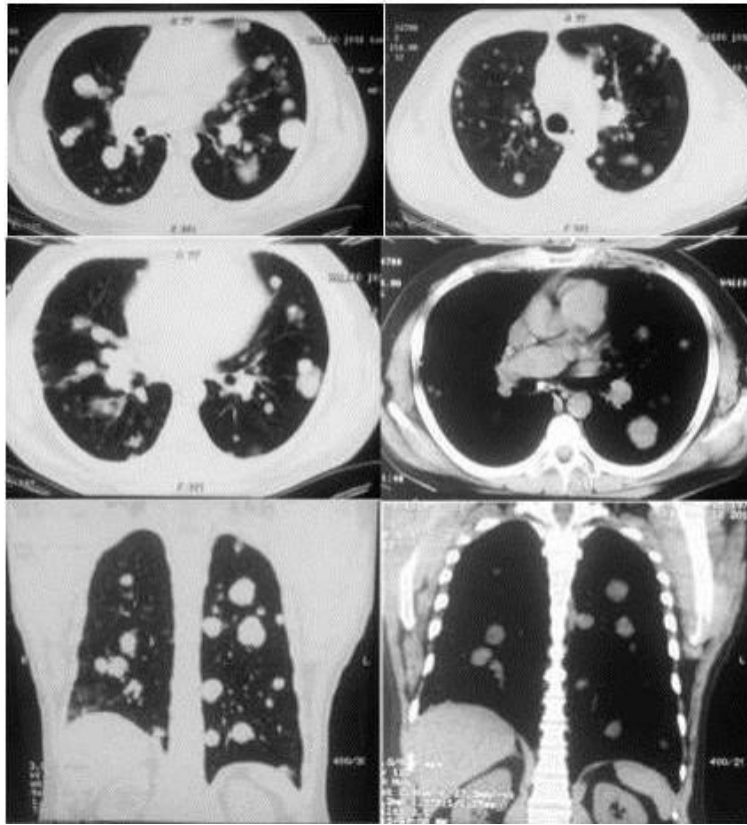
BRIGHT SPEED 16-detector chest CT: multiple nodular images bilaterally in the central and subpleural regions, ranging in size from 0.6 cm to 3.1 cm, with Hounsfield unit (HU) values between 23 and 43. Increased pulmonary attenuation with air bronchogram is noted, as well as bilateral peripheral ground-glass opacities, and thickening of the interlobular septa, predominantly in the basal regions
